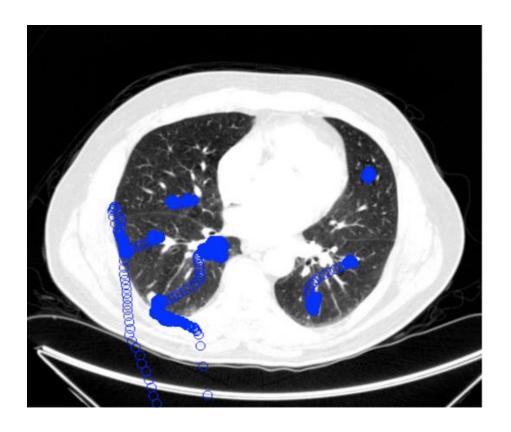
Chest CT scan with eye tracking
